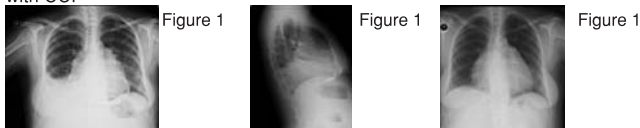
Radiograph of a patient with calcification in PA position
